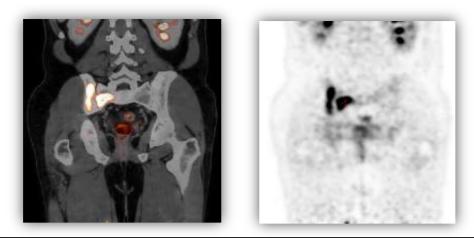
e: Coronal PET/CT image of the pelvis
